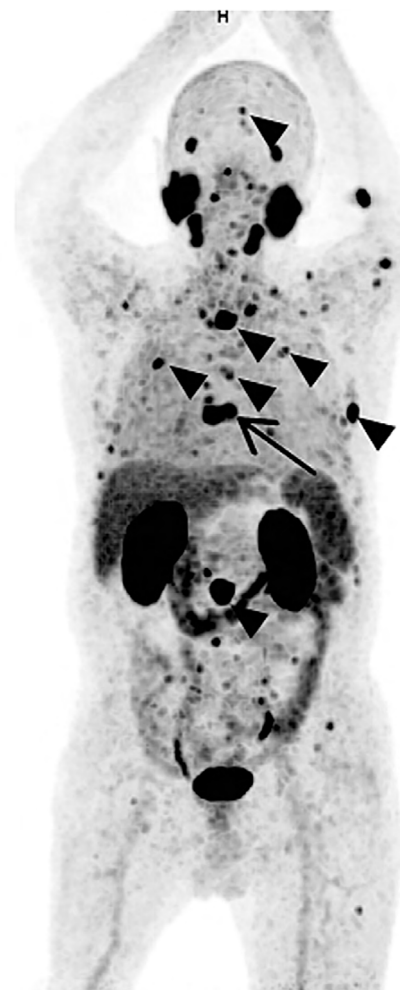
Maximum intensity projection (MIP) of $[^{68}\text{Ga}]\text{Ga-PSMA-11}$ PET/CT — arrow indicates the only focus of bone metastases which was visible in the bone scintigraphy, the arrowheads indicate some of many other foci of bone metastases
